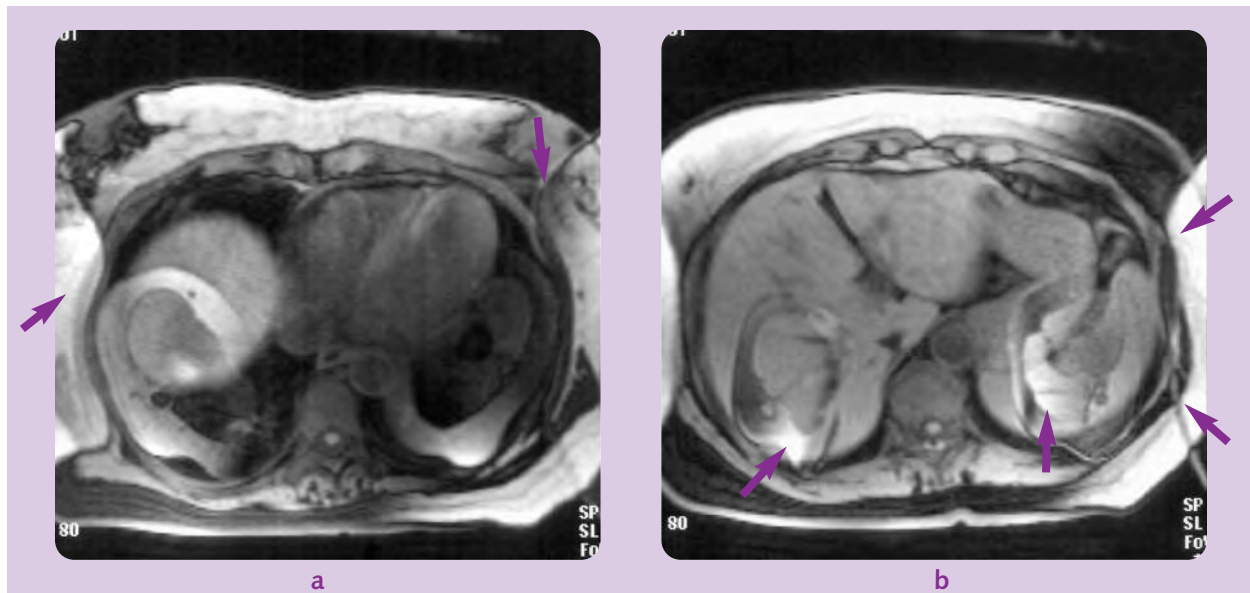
Axial T1-weighted breath-hold images with gradient reorientation. The phase-encode direction is now right to left. Wraparound artifact is seen (arrows) because the FOV was not appropriately increased.
